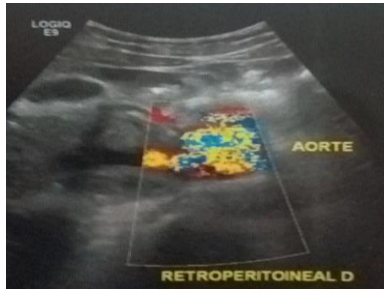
Dopler ultrasound view of an hemorrhagic saccular aneurysm of the renal artery
